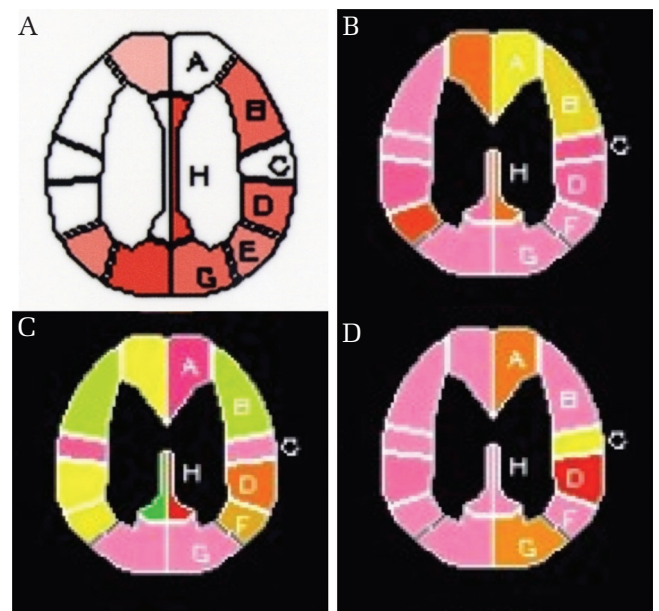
Serial change of cerebral vascular reactivity (CVR) in case 3 described as “% Increase Map”, proposed by Japanese Extracranial—Intracranial Bypass Trial (JET)-2 Study, showing the areal change in the Cerebral blood flow (CBF) followed by acetazolamide challenge with quantitative analysis of single photon emission computed tomogram.²⁷⁾ (A) Regions that are poorly reacted or showed decreased CBF (pale areas) are widely spread in the right hemisphere before the treatment. (B) CVR in the right hemisphere recovered 1 day after the first-stage angioplasty. (C) CVR in the right hemisphere partially deteriorated (yellowish areas) 2 days before the second-stage carotid artery stenting. (D) CVR well recovered 2 days following the CAS.
